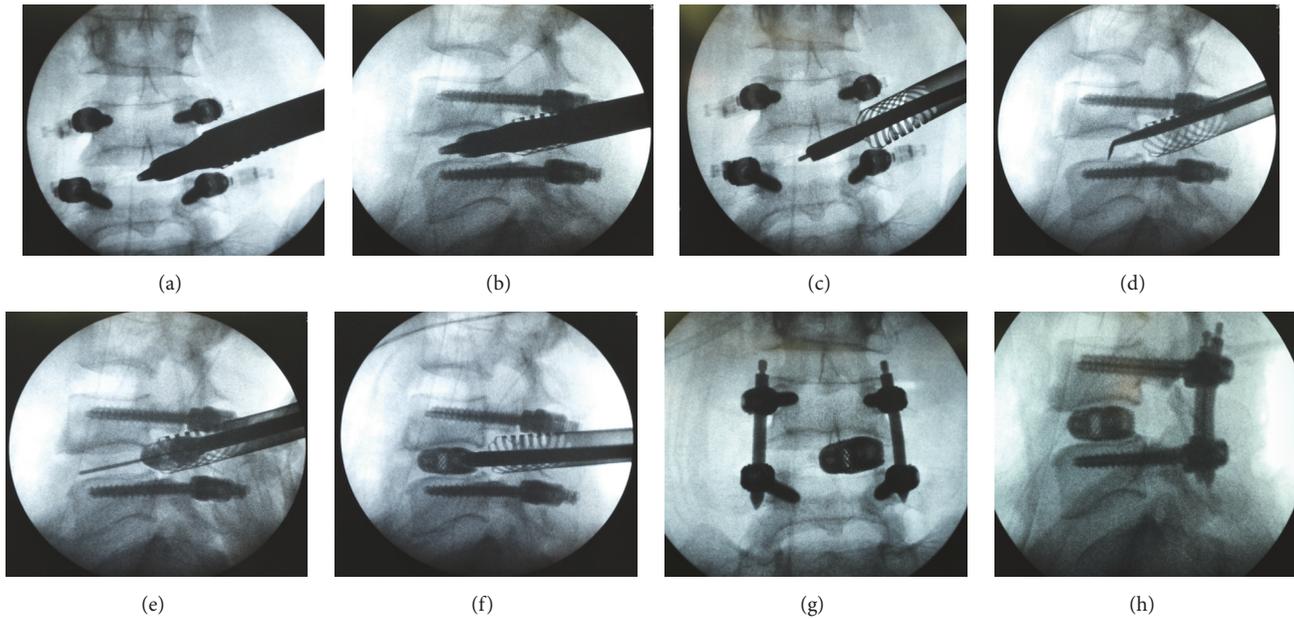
(a) and (b) Performing the dilation with the PELIF dilators until the desired diameter of the working tube. (c) and (d) Further removing intervertebral disc tissues and adequately endplate preparation. (e) and (f) Utilizing the guide wire to ease the cage placement under X-ray control. (g) and (h) Identification of the implant position by anteroposterior and lateral views.
